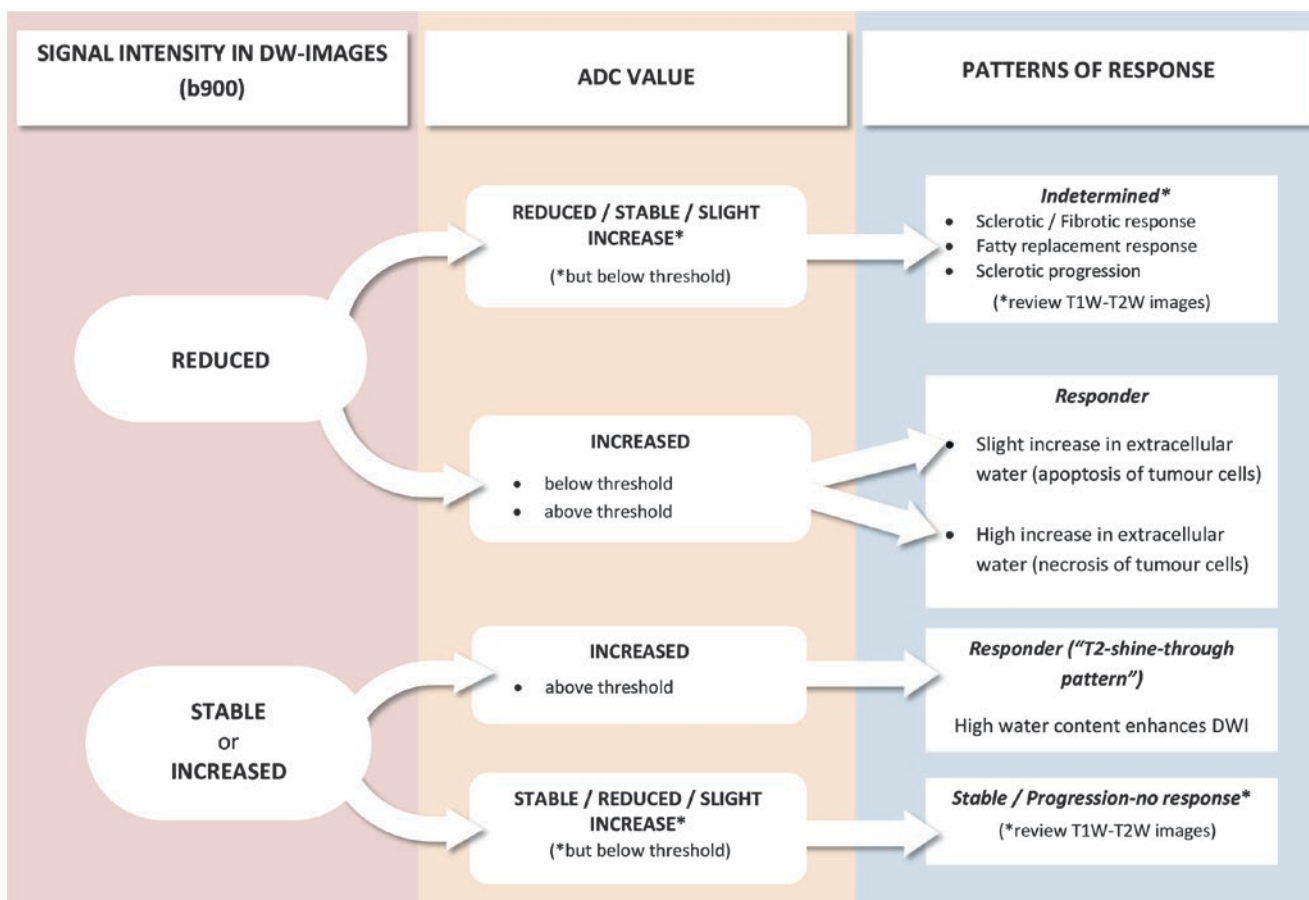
Proposed scheme for assessing therapy response of bone metastases using diffusion-weighted MRI scans, ADC measurements and morphologic images [adapted from *Therapy Monitoring of Skeletal*
